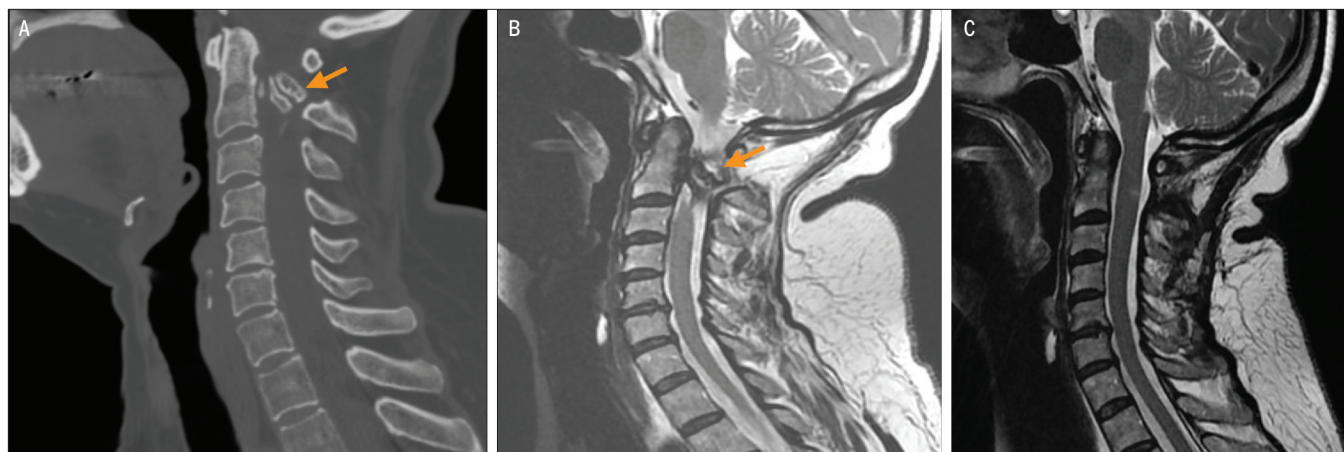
Sagittal plane images. (A) Cervical computed tomography showing intracanal stenosis by exostosis at the C1-2 level (arrow). The exostosis came off C2. (B) T2-weighted magnetic resonance imaging showing spinal cord compression. (C) Postoperative, T2-weighted magnetic resonance imaging 6 months after surgery showing small foci of residual high T2 signal in the spinal cord.
